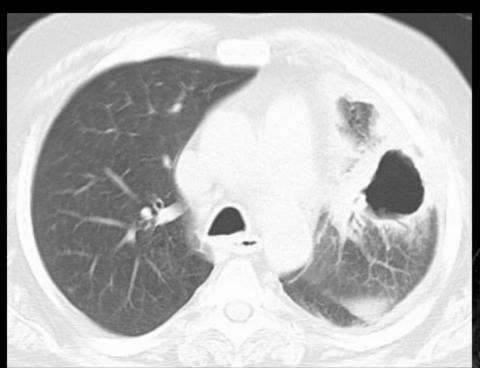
Man, 82 years old with hemoptysis and dyspnea. Thoracic CT shows a hilar mass which invades the right upper lobe and causes collapse of the respective lung segment. The posterior border becomes convex due to the tumor (Golden's S sign).
